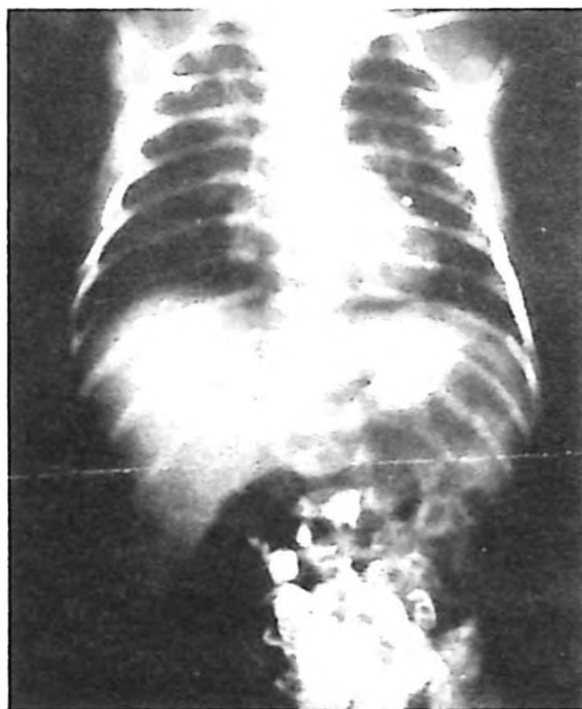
Baby's chest x-ray: No signs of foreign body seen.
